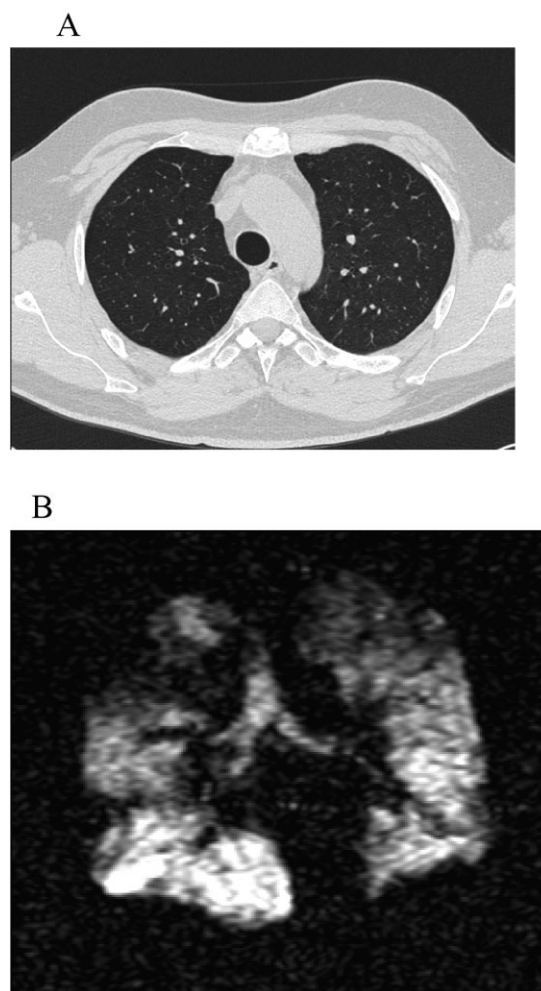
Comparative images in a patient with subsequently proven bronchiolitis obliterans. A: HRCT image demonstrating normal lung parenchyma. B: Corresponding hyperpolarized 3-He MR image with ventilation defects.
